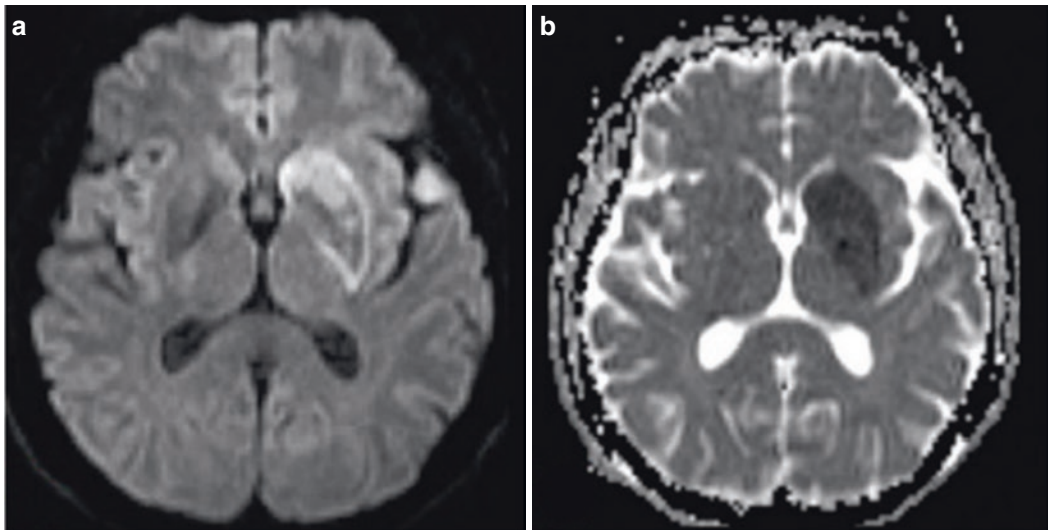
Hyperacute cerebral infarction. A 48-year-old male patient with sudden weakness and numbness in his right limbs. Transverse DWI shows hyperintense signals
